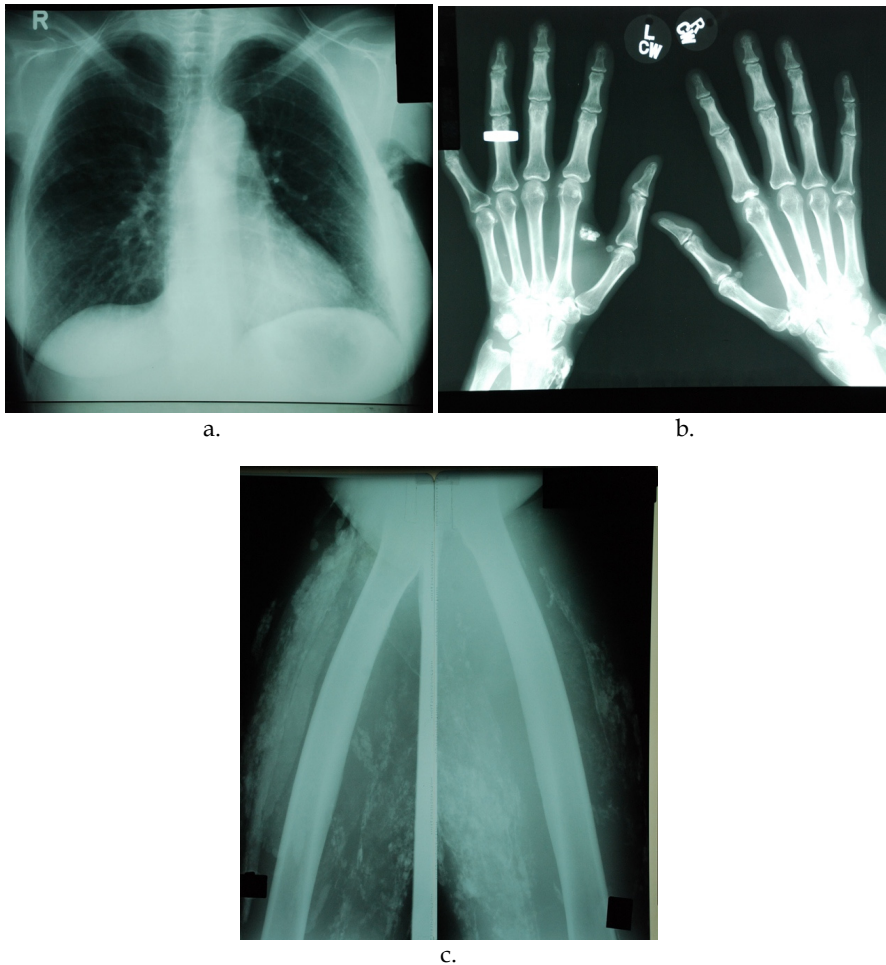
a-c. Case 2. A 41-year-old woman with known clinical manifestations of dermatomyositis was referred for radiographs of the chest, hands, and thighs. Ultrasound of the thighs was also performed. The PA chest X-ray demonstrates a thick shell of plaque-like calcifications within the superficial soft tissue (Fig. 2a). The PA radiograph of the hands shows more discrete and dense calcific areas, and also soft tissue loss relating to the tips of some of the fingers (Fig. 2b). Radiography of the thighs reveals multiple dense calcified plaques involving the muscles of both thighs (Fig. 2c).
